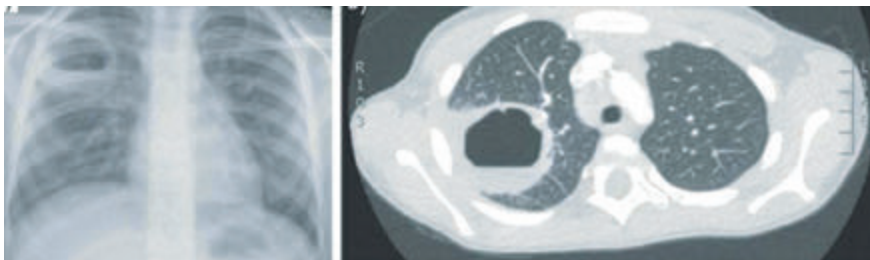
Abscess with a fluid level in CXR and CT scan
